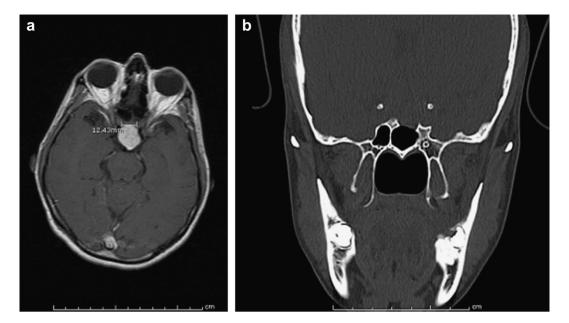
(a) Axial contrast image showing a residual pituitary adenoma with a cavernous intercarotid distance of 1.7 cm; (b) CT bone window showing the previous entry site close to the petrous and cavernous ICA.
